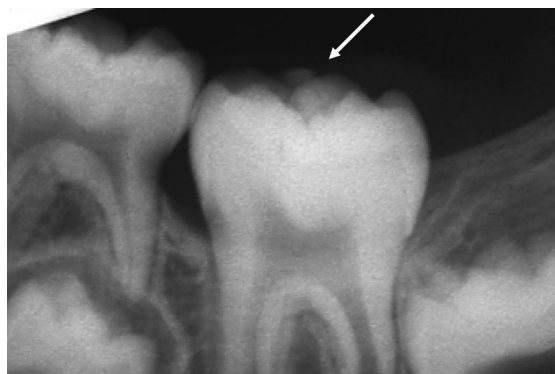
Periapical radiograph taken at the first visit
